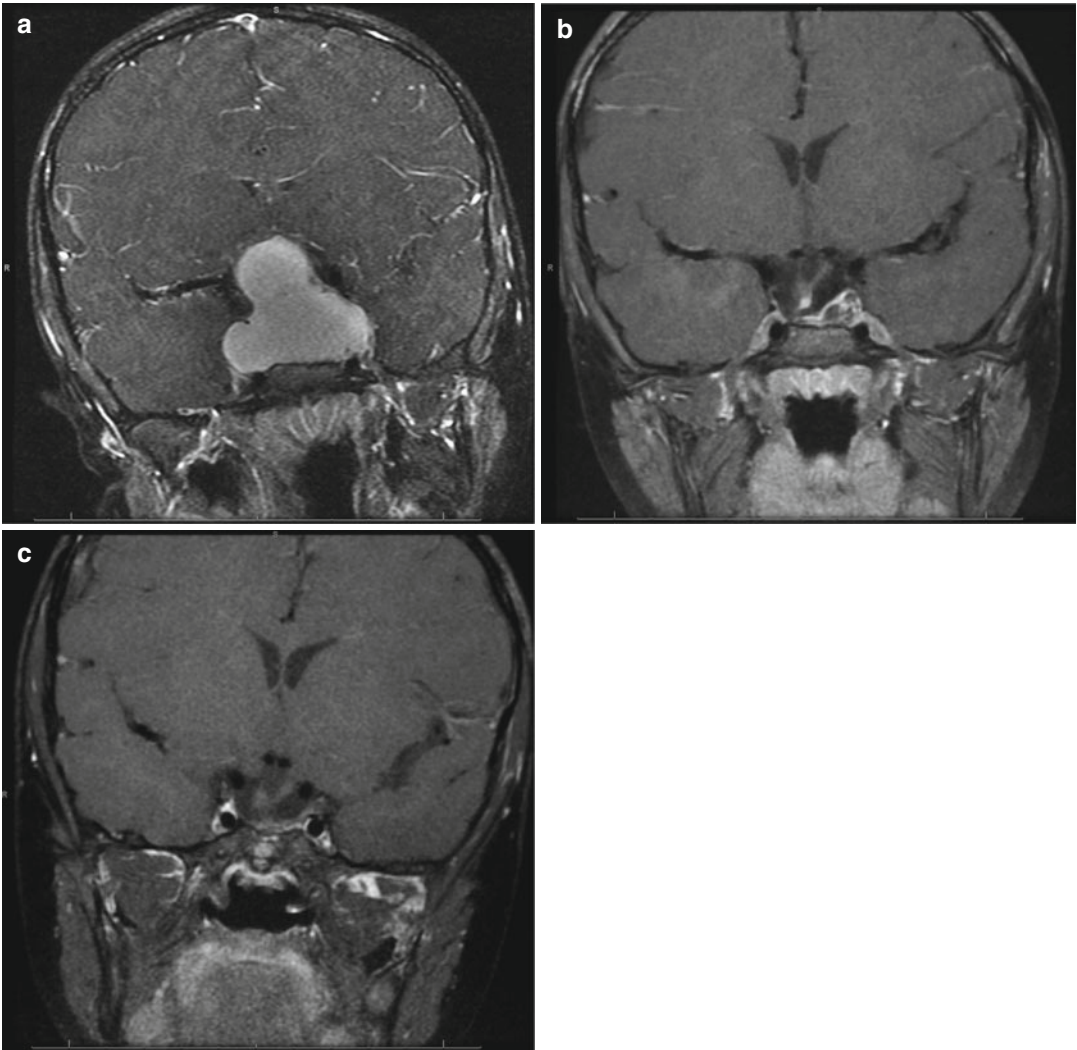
(a) Coronal T1-weighted image with contrast showing a large cystic suprasellar craniopharyngioma in a 4-year-old girl. (b) Six months following a transsphenoidal procedure, the cyst is completely decompressed with a small residual lesion along the left side of the sella. This
